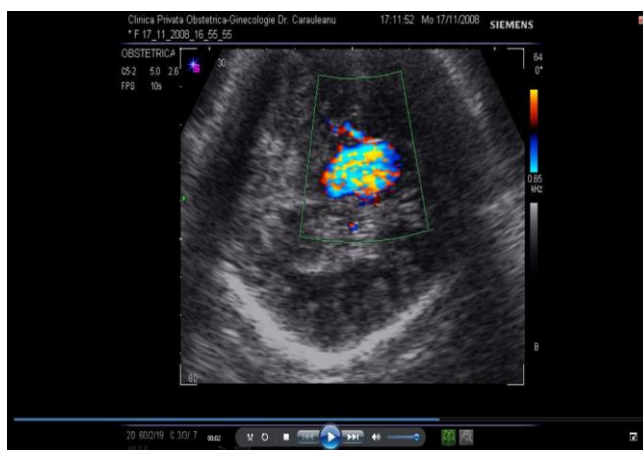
Color Doppler image in the aneurysm.
